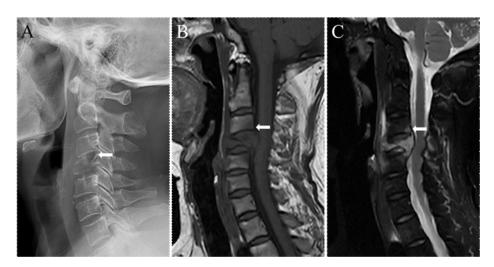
A cervical spine radiograph (A), and magnetic resonance imaging (MRI) of the cervical spine demonstrated the lytic lesion with collapse of the C4 vertebral body. MRI T1WI (B) and T2WI (C) series demonstrated the compression of the dural sac and cervical spinal cord and the focal invasion in the posterior aspect of vertebral body of C3 lesion.
